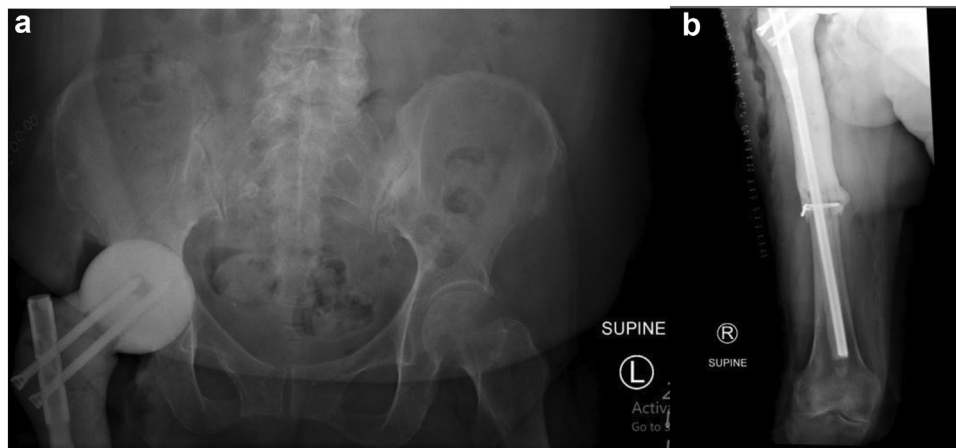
Postoperative radiographs after antibiotic spacer insertion. (a) Postoperative anterior-posterior view of the pelvis demonstrates the prefabricated spacer head with screw fixation to the intramedullary nail in anatomic position in the acetabulum. (b) Postoperative anterior-posterior view of the femur demonstrates intramedullary nail fixation into the midshaft and distal femur, cerclage wire fixation, and antibiotic-impregnated cement surrounding the nail.
